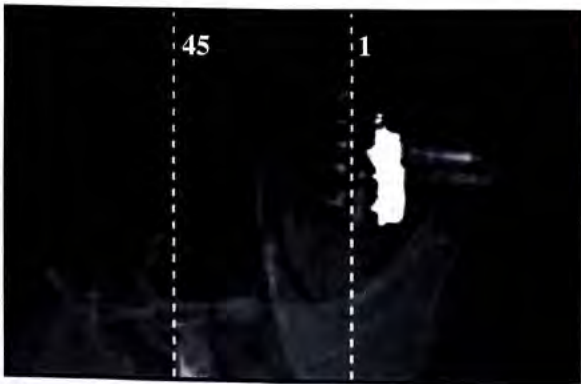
Scout view of maxilla is a cephalometric view, obtained by the CT technologist before any axial slices are taken.
